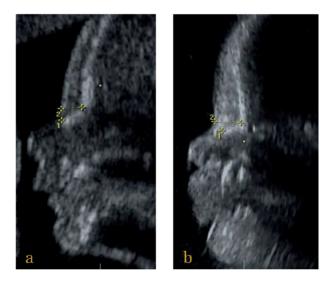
Ultrasound images of a normal fetus (a) and a DS fetus (b) showing nasal bone length (caliper 1) and prenasal thickness (caliper 2) measurements.
